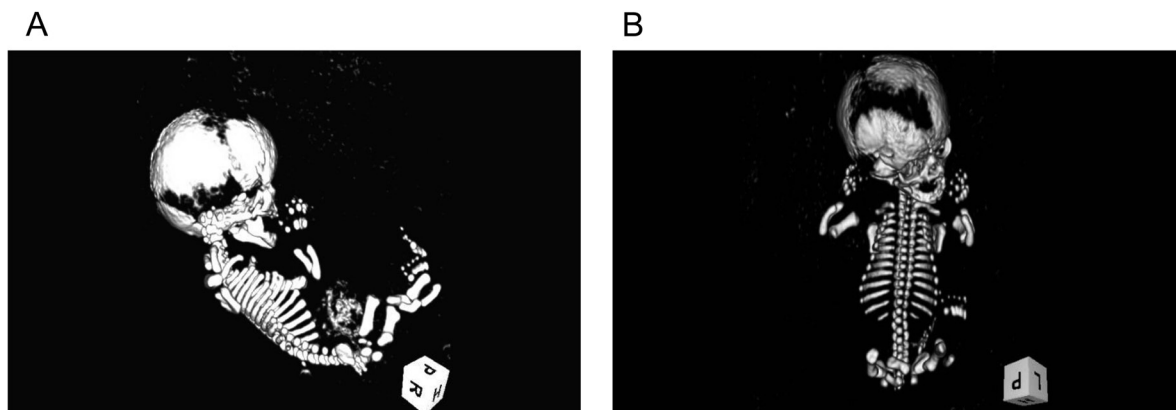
Fetal CT scan at 27 wk of gestation. (A) Lateral image, (B) frontal image. Skull enlargement, frontal bossing, shortened extremities, small thorax, and pelvic hypoplasia are seen.
